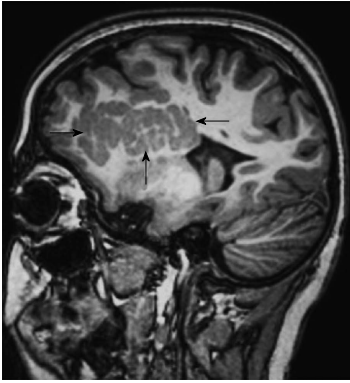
A 12-year-old boy with subcortical heterotopia. Sagittal 3D T1-weighted image shows large nodular form subcortical heterotopia (arrows) extends from the ventricle into the white matter in frontotemporal region.
